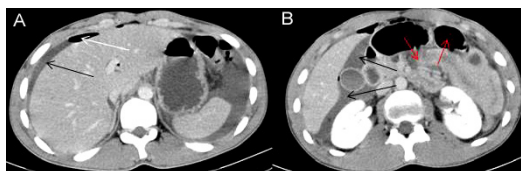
CT scan. Axial section. A. Pneumoperitoneum (white arrow) and perihepatic free fluid (black arrow) are visualized. B. Free fluid (black arrows) and distended loops of small intestine (red arrows).
